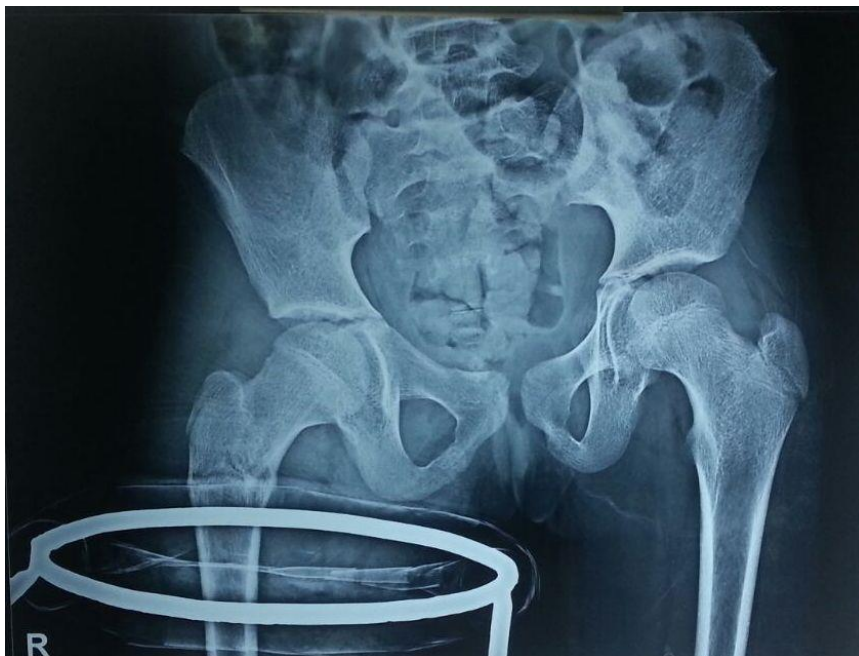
Pre-operative x-ray of pelvis with both hip showing undisplaced Sub trochanteric femur fracture
